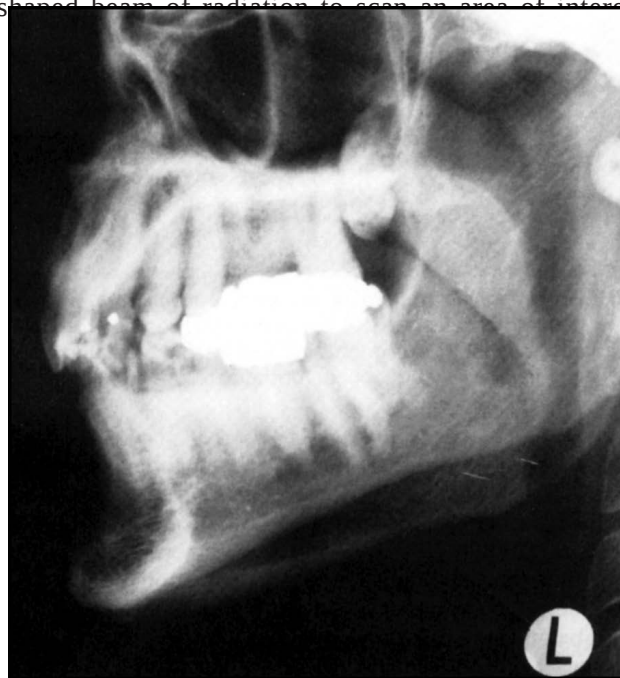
Lateral linear scanogram of the maxillofacial area. Maximal image contrast is obtained by using linear scanning techniques rather than standard radiography
